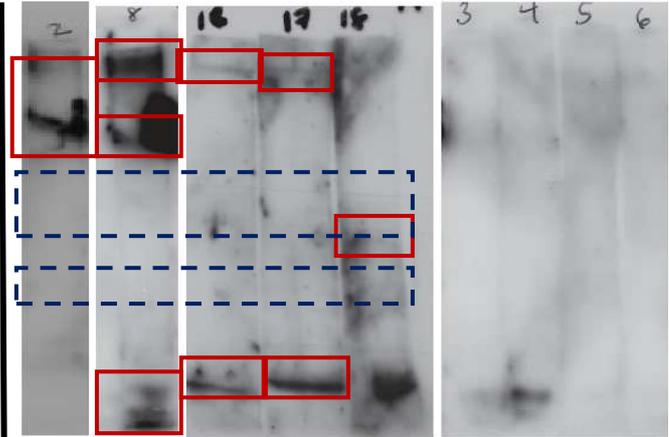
Western blot immunoassay NCC-positive sera samples compared to select Western blot immunoassay NCC-negative sera samples. The 5 samples on the left are the samples considered to be positive by Western blot immunoassay; samples 2 and 8 (far left) are those that were found to be positive by CT scan. Red boxes mark the bands while the blue dashed boxes mark the approximate locations of the bands of the positive control. The 4 samples on the right are negative samples and are provided as points of comparison to the positive
